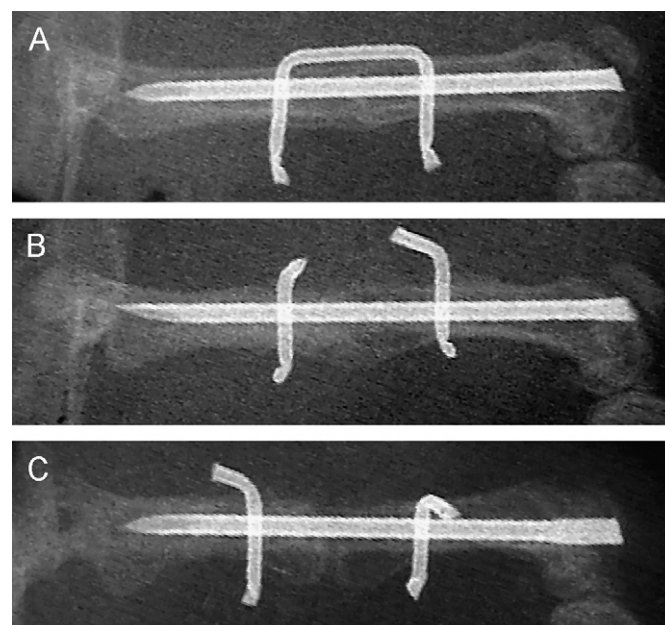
Representative X-rays of right femora at 5 weeks after pin-clip (A) and unstable (B and C) fixation of the osteotomies. The more stable fixation regularly showed adequate radiological healing (Goldberg 2, A). Unstable fixation resulted frequently in only possible radiological union (Goldberg 1, B) or, occasionally, in radiological non-union (Goldberg 0, C).
